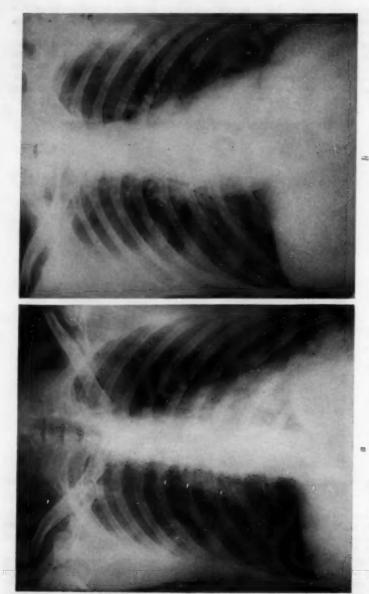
Roentgen chest study demonstrates left pulmonary atelectasis. b. Restudy three days later demonstrates a normal chest x-ray except for slight elevation of the left diaphragm.
